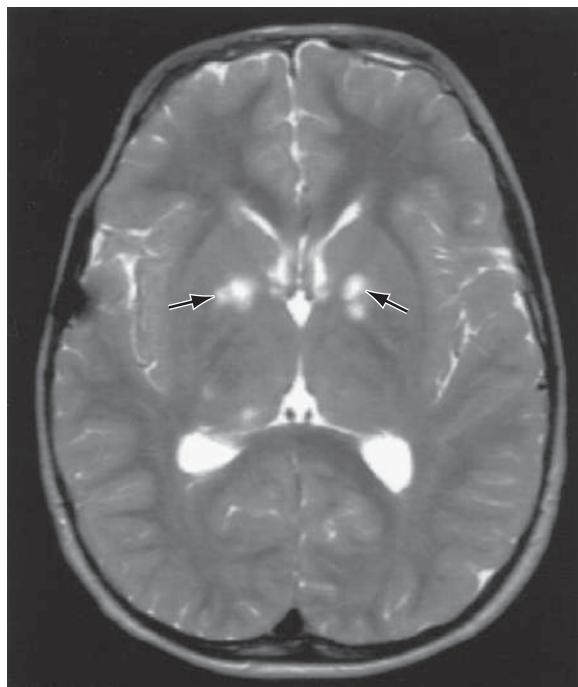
T2-weighted MRI scan of a patient with NF1. Note the high-signal areas (unidentified bright objects or focal areas of signal abnormality [FASIs]) in the basal ganglia (arrows).
